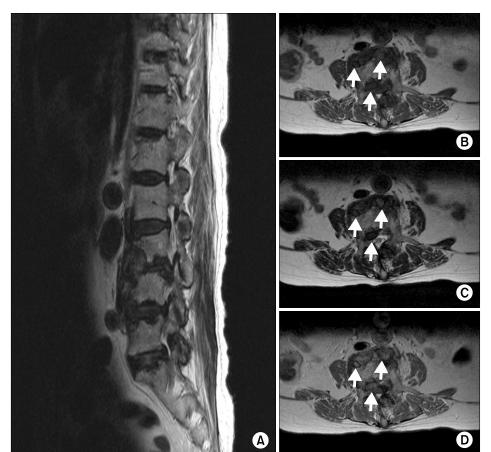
Lumbar magnetic resonance imaging. Multiple well-defined bony erosions adjacent the disc space from 2nd to 5th lumbar vertebrae are revealed on T2-weighted image (A). T1-weighted image (B) and T2-weighted image (C) show well-defined bony erosions and extraosseous extension (arrows) and low signal intensity at 3rd and 4th lumbar vertebrae. In the contrast-enhanced T1-weighted image, these lesions are diffusely enhanced (D).
